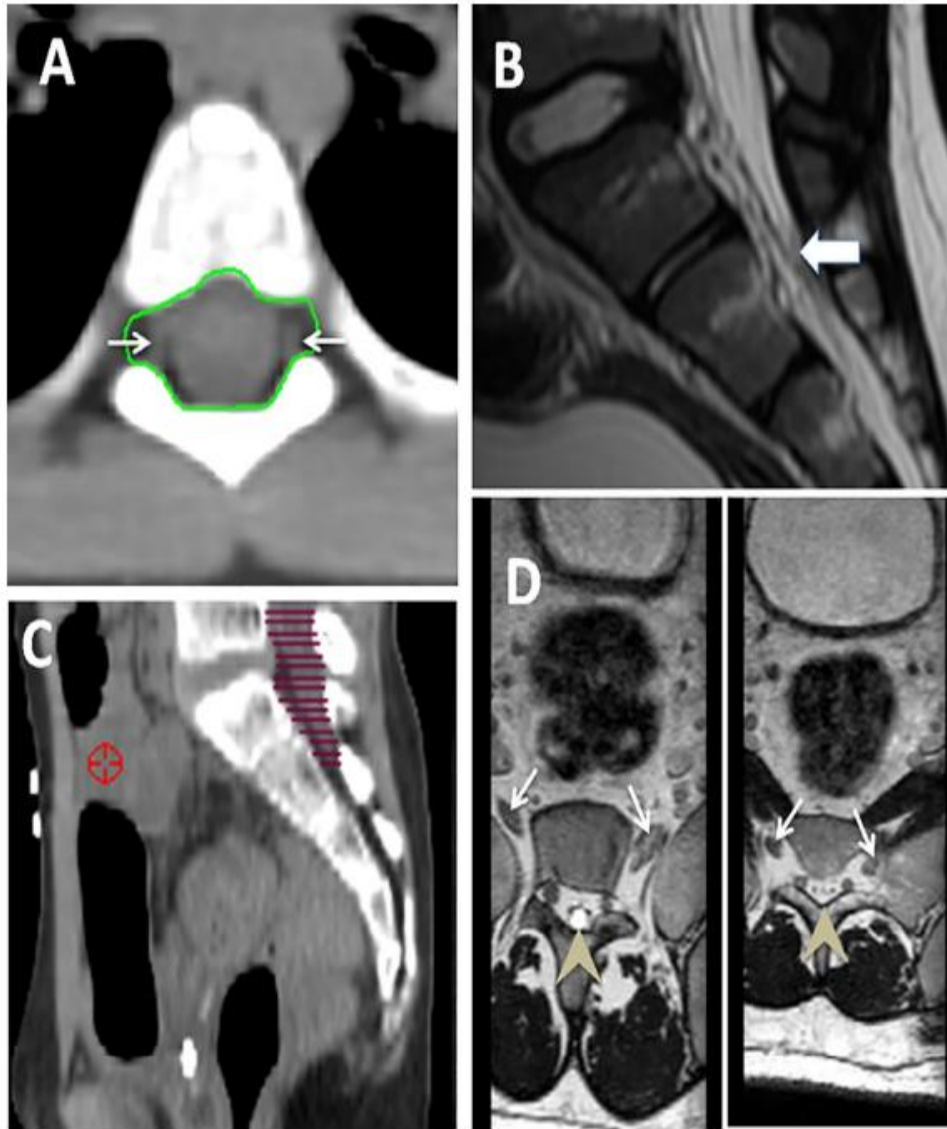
(A) CTV_{spinal} including the entire arachnoid space with nerve roots (white arrows). (B) Lower level of CSF (white arrow) on sagittal T2W MRI, (C) Lower limit of CTV_{spinal} on planning CT scan, (D) Absence of CSF around sacral nerve roots (white arrows). Note CSF within spinal canal (arrow heads).
